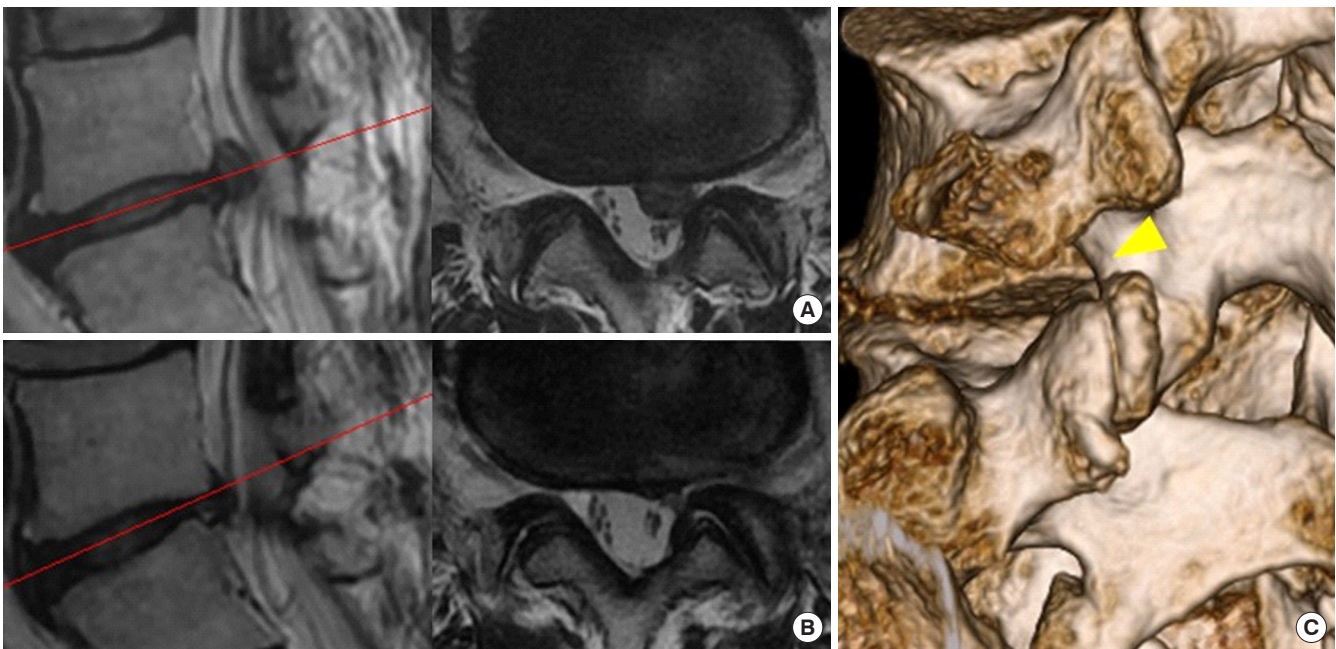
Representative case without superior articular process (SAP) removal. Preoperative (A) and postoperative (B) magnetic resonance (MR) images of case 9. Sagittal (left) and axial (right) T2-weighted MR images are shown (the red line on the left sagittal image indicates the level of the right axial image). (C) Three-dimensional computed tomography finding of case 9. This case has no SAP hypertrophy; consequently, the entry point on the L5/S1 disc surface is exposed (arrowhead).
